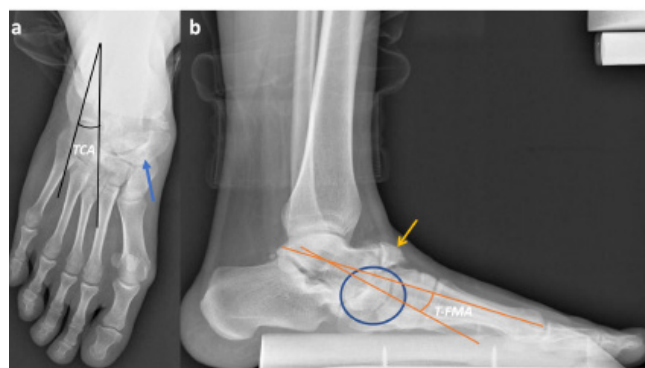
Anteroposterior radiograph (a) shows the characteristic changes in the navicular bone secondary to Mueller-Weiss syndrome: compression and collapse of the lateral part of the navicular and subsequent development of comma shape (blue arrow). Note that TCA (talocalcaneal angle) refers to the angle between lines drawn from the lateral border of the calcaneus and axis of the talus. Lateral radiograph (b) shows condensation, fragmentation, and collapse of the navicular (yellow arrow). Note that T-FMA (talus-first metatarsal angle) indicates the angle between lines drawn from the longitudinal axis of the talus and first metatarsal.
